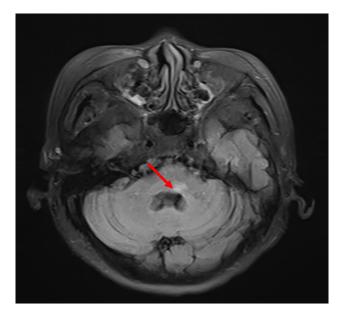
MRI results of patient 5. MRI showed high Flair signals (red arrow) in the left medulla.
